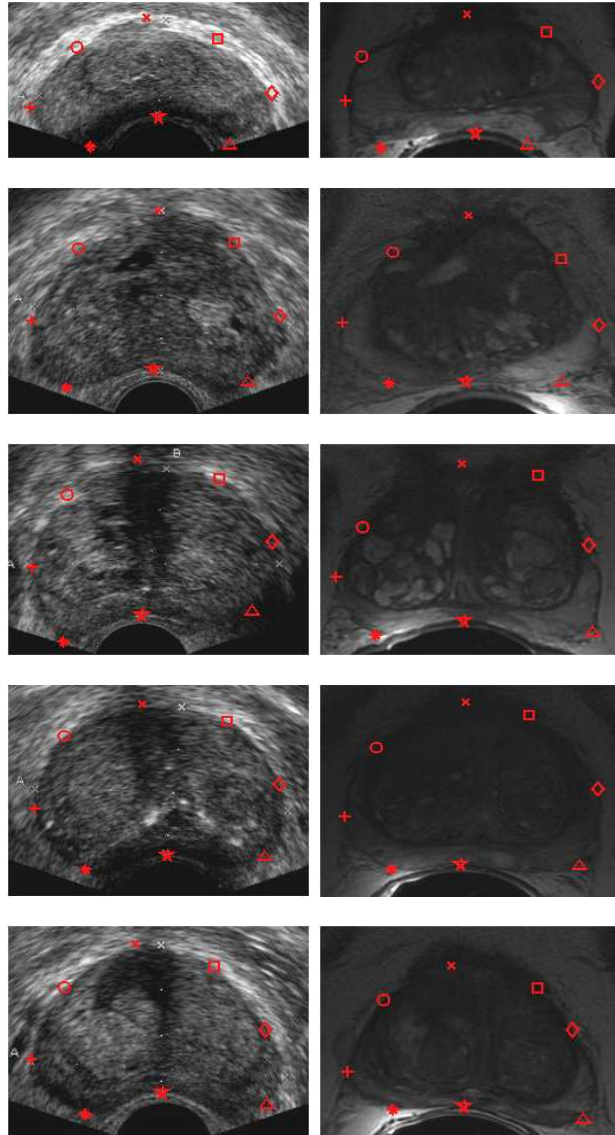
Point correspondences on TRUS and MR prostate contours using Bhattacharyya distance. The left column shows the TRUS images and the right column shows the MR images. The MR images show more deformed prostates than those on the TRUS images. The 8 point correspondences are marked in 'red'.
